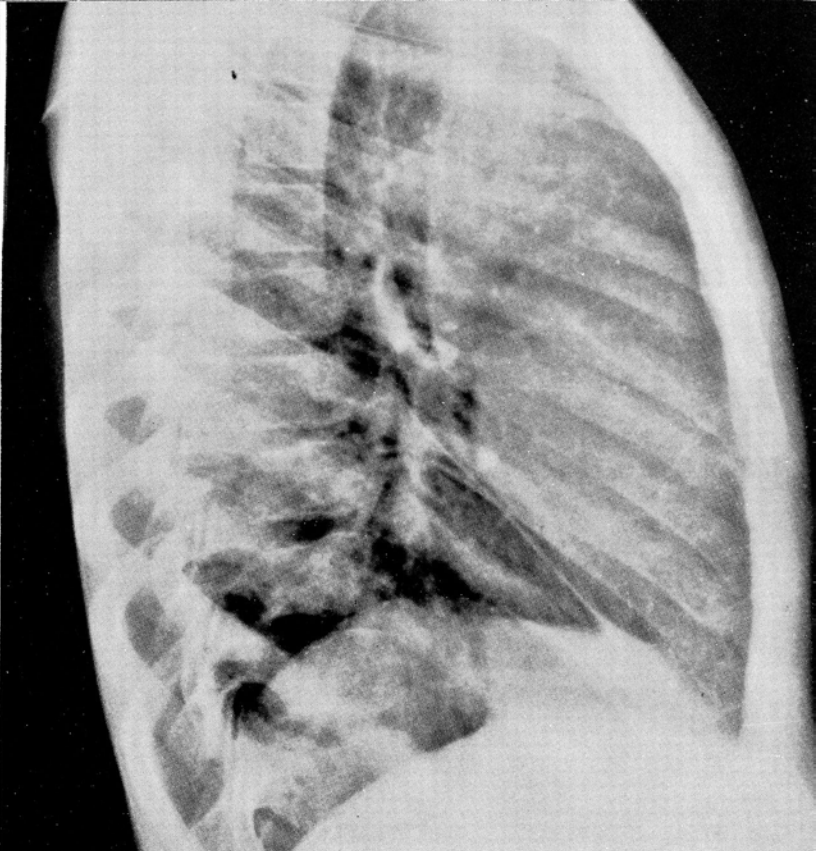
Lateral roentgenogram shows anterior situation of tumor.
